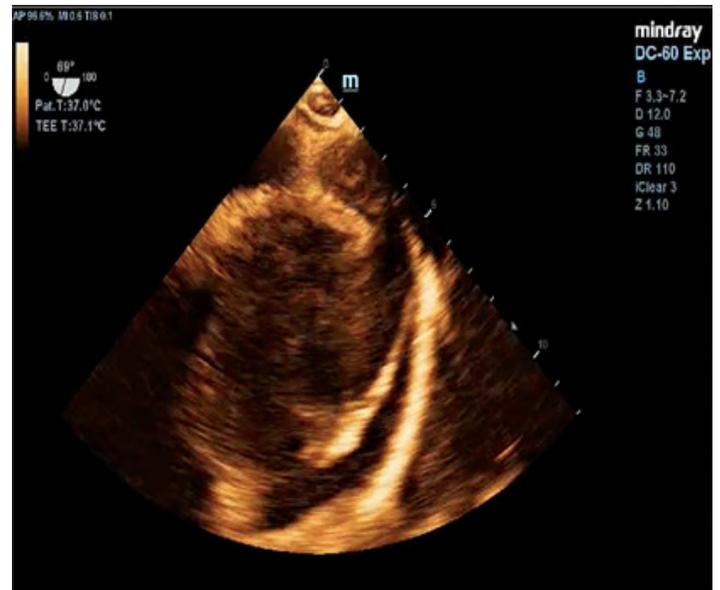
Transesophageal echocardiogram (longitudinal view).
